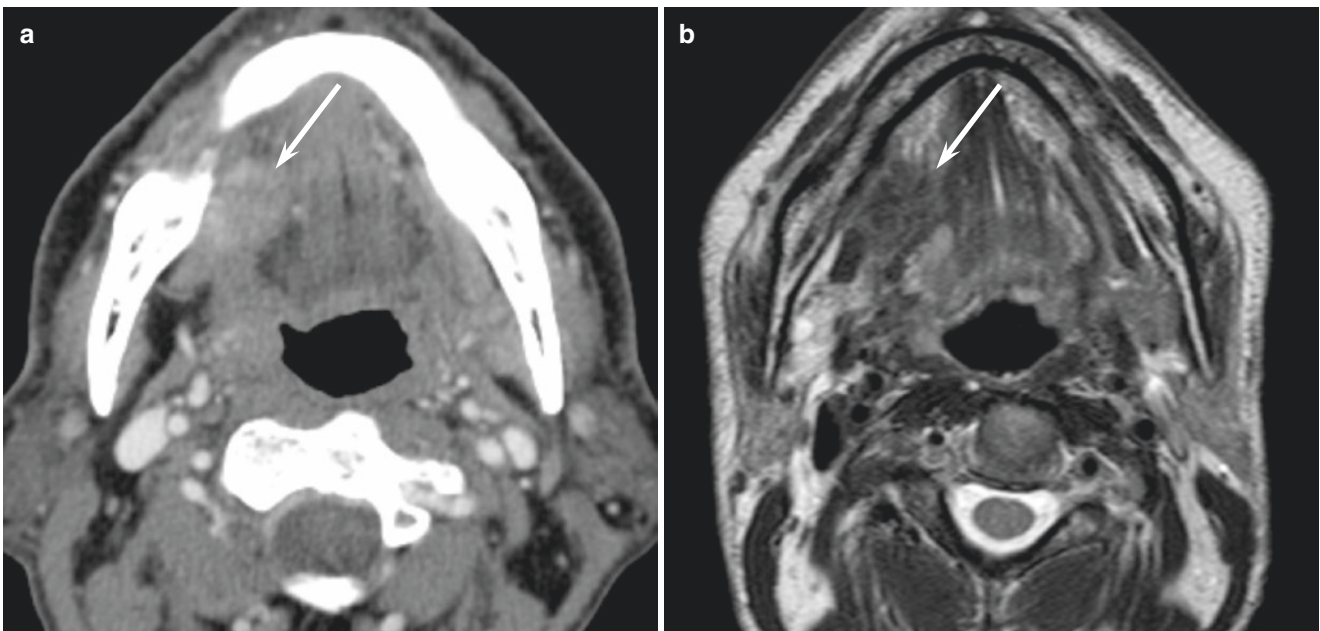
A 74-year-old man with low-grade mucoepidermoid carcinoma of the right sublingual gland. (a) Contrast-enhanced CT image shows an ill-defined, heterogeneously enhanced lesion (arrow). (b) T2-weighted image shows an ill-defined, heterogeneously hypointense lesion (arrow)
